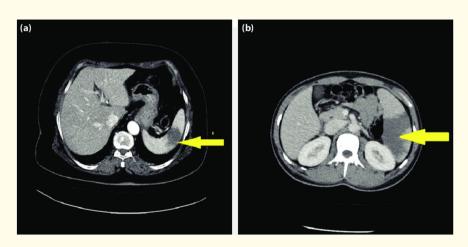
CT scan showing huge splenic infarction (Yellow arrow).
